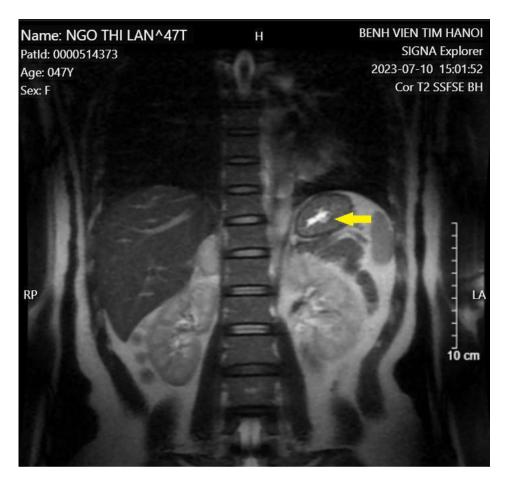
Abdominal MRI scan with T2-weighted sequence. (the yellow arrow indicates an adrenal tumor)
